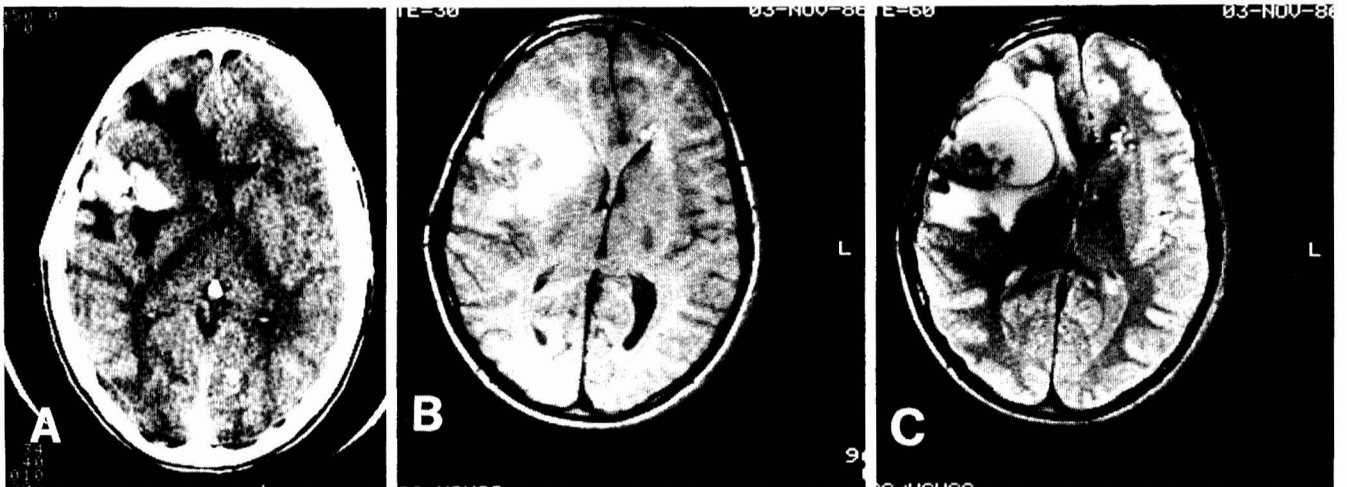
Case 3. *A*: Non-contrast enhanced CT scan demonstrating a partially hemorrhagic, heavily calcified mass with surrounding edema. *B* and *C*: T1-weighted image and T2-weighted image showing hyperintense free methemoglobin anterior to mixed tissue matrix and calcification, with surrounding edema. Note the second, smaller malformation adjacent to the left frontal horn, also containing subacute blood, seen on the CT scan only in retrospect.
